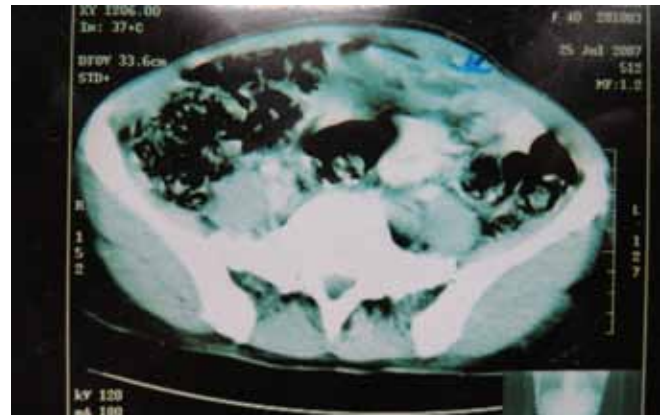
CT scan of abdomen showing hyperdense shadow within swelling suggestive of a foreign body.
